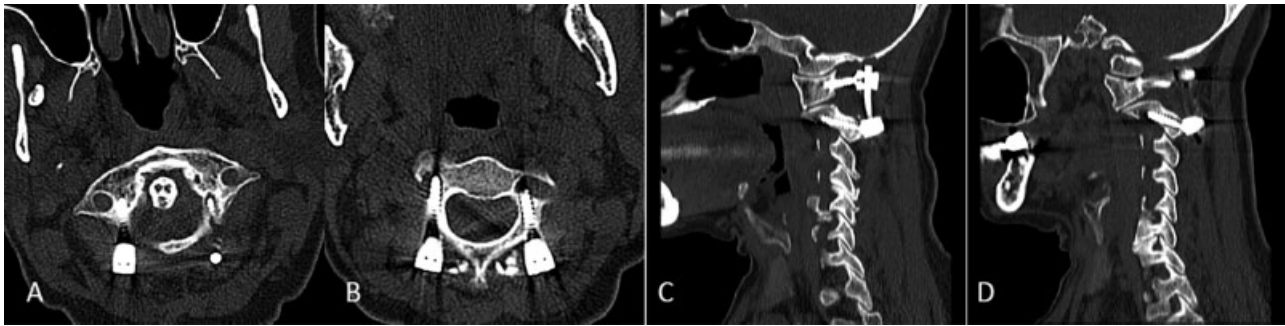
Postoperative CT of second patient. (A) Screws of C1. (B) Screws of C2. The right C2 pedicle screw has breach into transverse foramen. (C) Sagittal view of right side screws. (D) Sagittal view of left side screws. CT, computed tomography.
